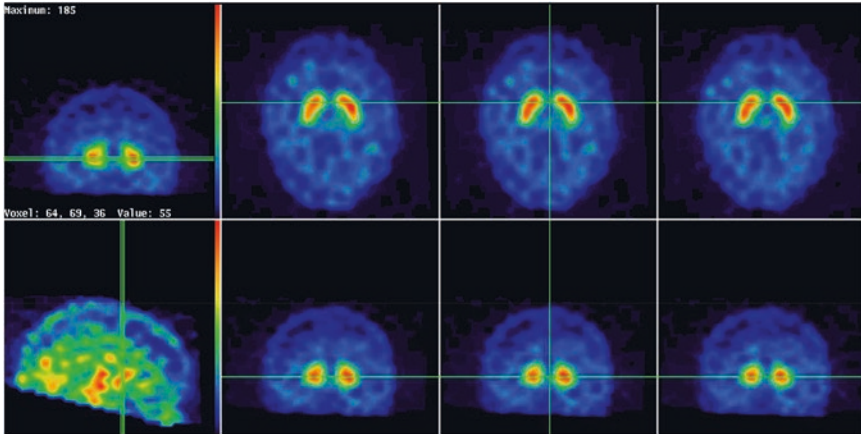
SPECT brain imaging to assess the dopamine active transporter system (DAT scan). A DAT brain scan is often used to help distinguish Parkinson's disease from other causes of tremor or movement difficulties. Iodine-123—FPCIT (Ioflupane) was administered. There is normal uptake in the striatum—bilaterally
